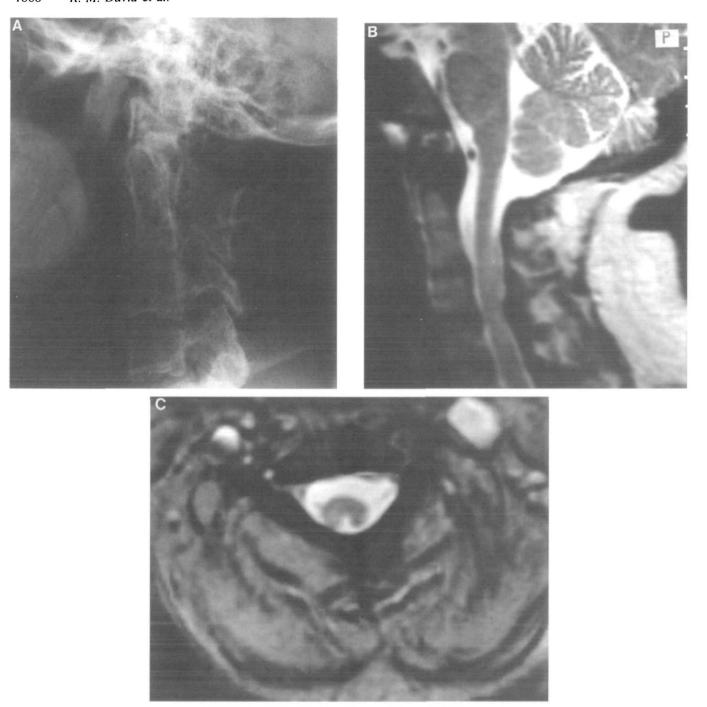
Case 7. (A) Lateral cervical roentgenogram showing partial assimilation of C1 to occiput posteriorly and C2/3 fusion. (B) Sagittal MRI (T₂-weighted image) demonstrating capacious upper cervical canal and foramen magnum. (C) Axial MRI (T₂-weighted image) with partial posterior splitting of the upper cervical cord.
